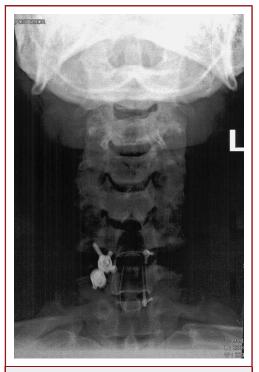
Anteroposterior radiograph of the cervical spine postoperatively with hardware in place.
